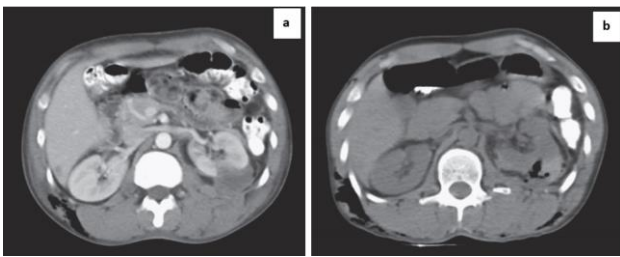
a) and b) Stab injury left flank: axial plain and contrast CT demonstrates renal laceration with perinephric haematoma and air in subcutaneous tissues.
